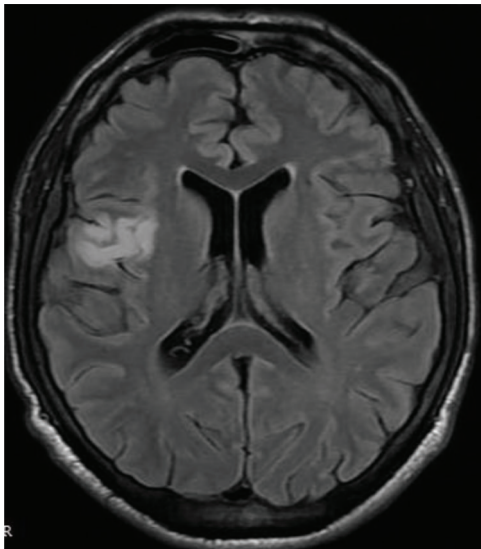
MRI brain/T2 Flair showing acute infarction in the right frontal supra-insular region.
